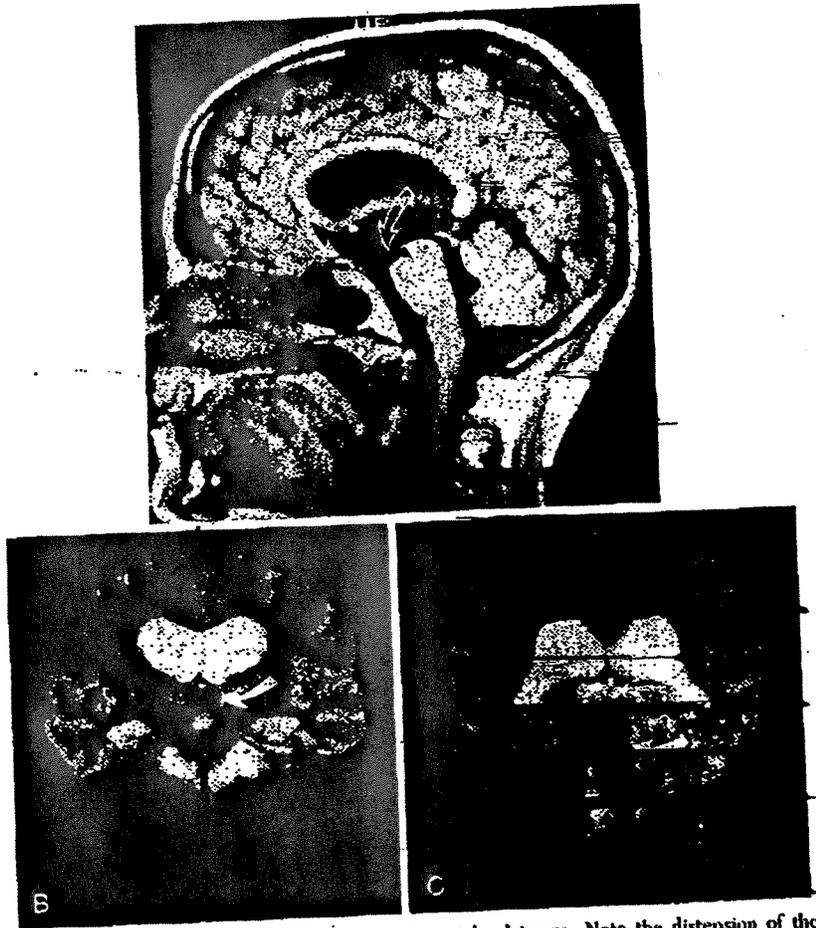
MRI in NPH. A, a sagittal T1-weighted image. Note the distension of the anterior inferior recesses of the third ventricle (solid arrow) and depression of the floor of the third ventricle (open arrow). B and C are coronal T2-weighted images. There is enlargement of the ventricles (including the temporal horns) relative to the sulci. There is also pronounced loss of signal (CSF flow-void sign) due to turbulence in the posterior third ventricle, aqueduct, and fourth ventricle (arrow).
